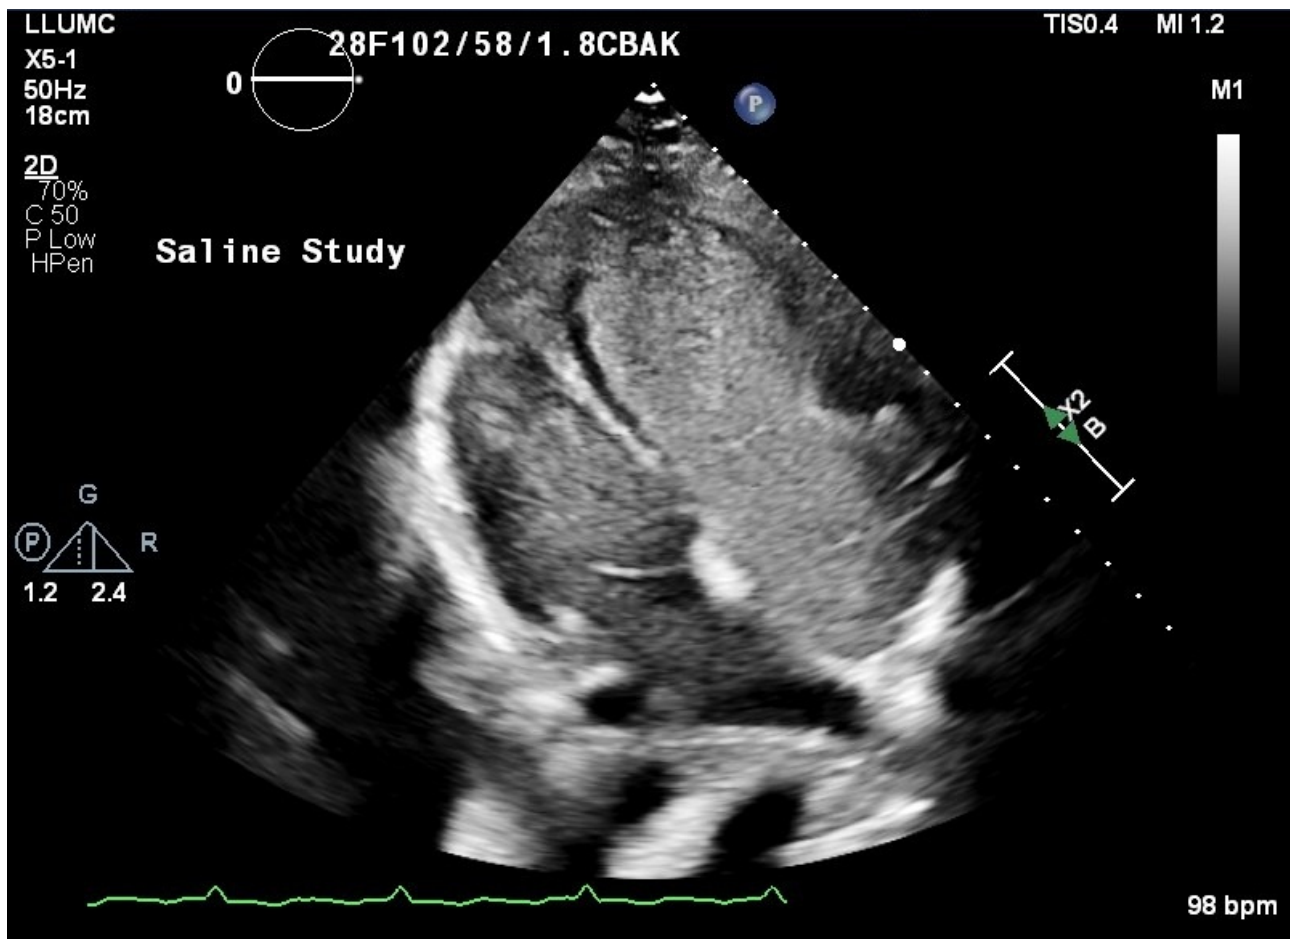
Trans-thoracic echocardiography visualizing an apical four chamber view with saline contrast from 1 year prior to presentation. Demonstrates right to left shunt as contrast flows from dilated right heart to left heart via atrial septal defect.
